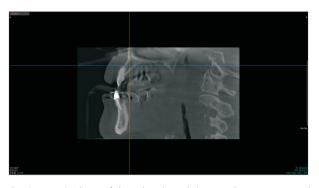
A sagittal cut of the related tooth in cone-beam computed tomography scans, horizontal root fracture was hard to recognize.
